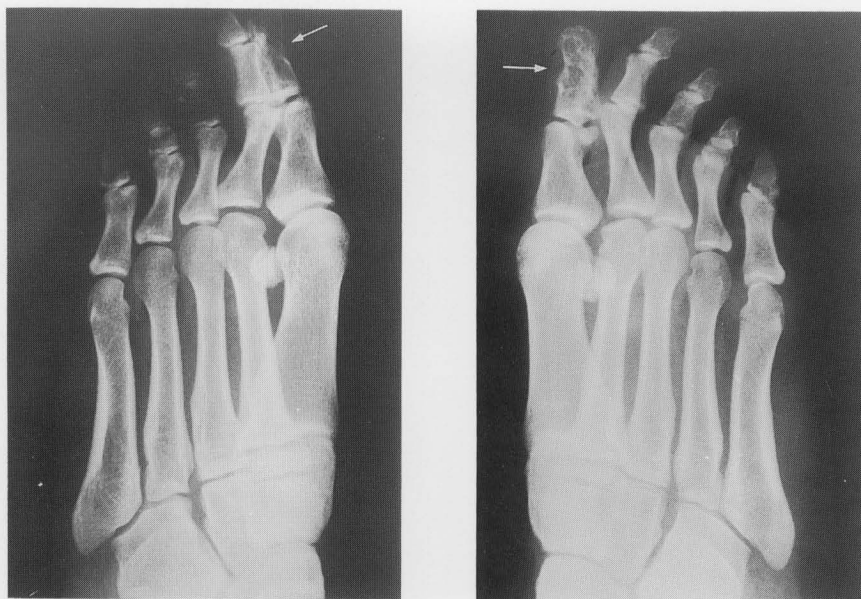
Plain roentgenograph showing osteolytic lesions within the phalanx of bilateral toes.
